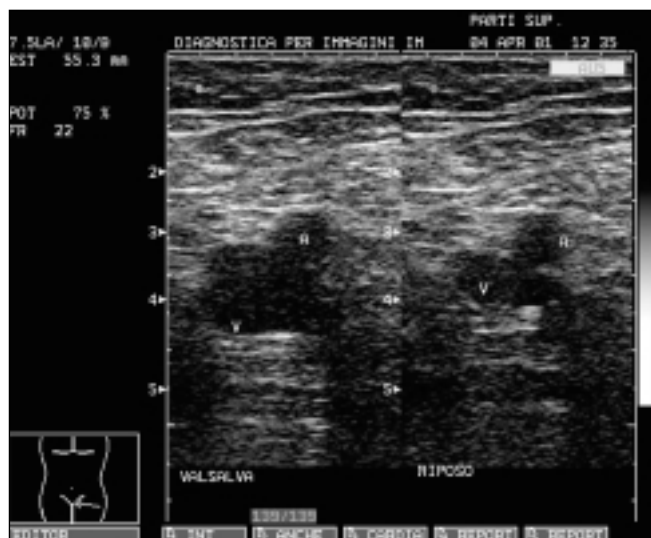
and Fig. 2 - Ultrasound images of femoral vein (V) and artery (A) showing the increase in femoral vein diameter upon performing the Valsalva maneuver: before and during Valsalva.
